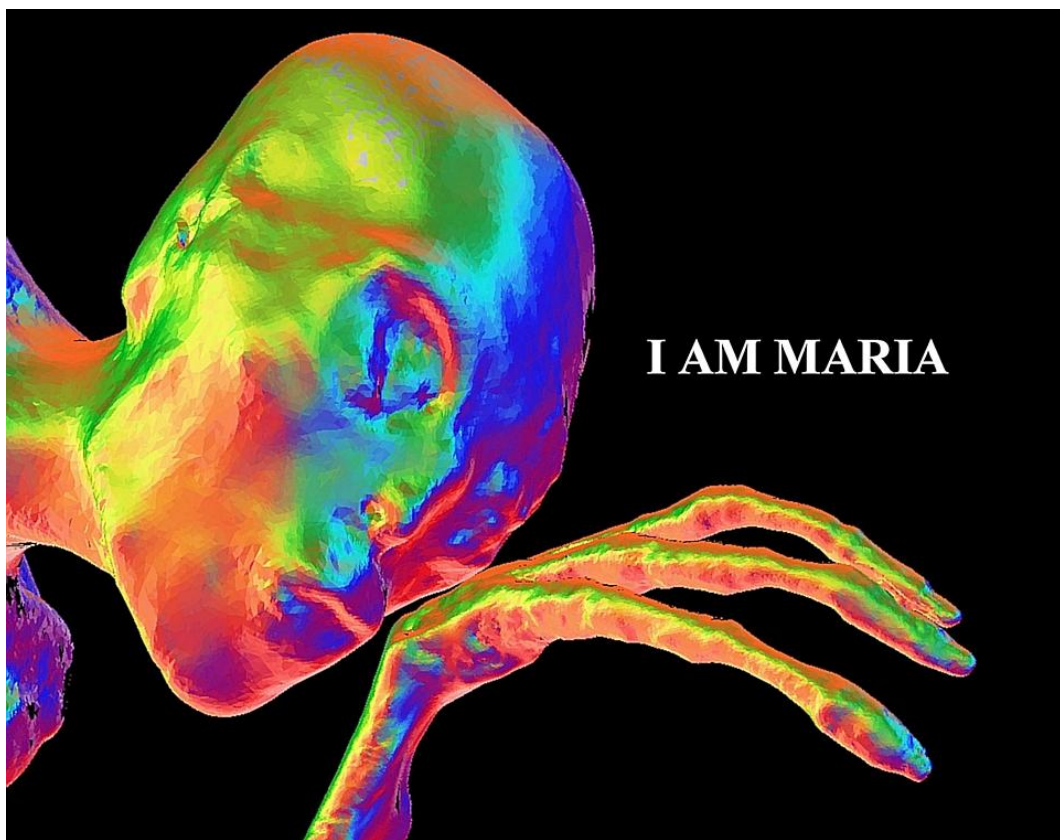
Artwork created from 3D CT showing the face of 'Maria' and her tridactyl hand with very long fingers.
